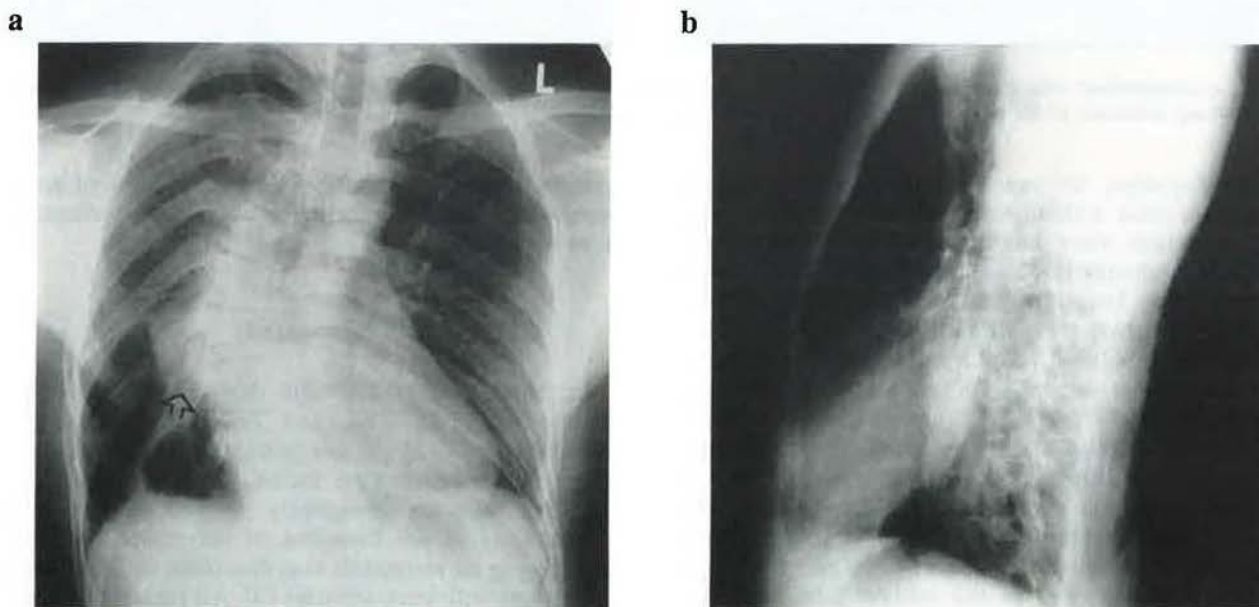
Postero-anterior (a) and left lateral (b) chest radiographs. Note the spine deformity (lordoscoliosis) which causes atypical appearance of the right lower lobe atelectasis (arrow).
